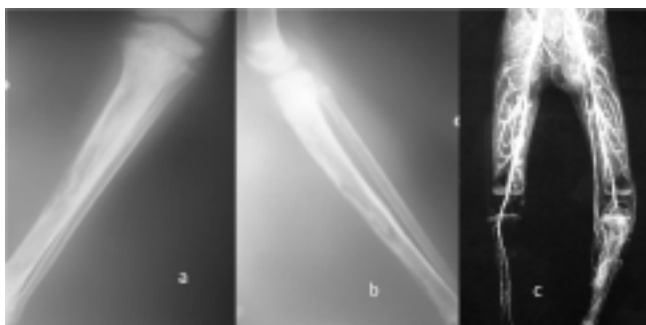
Antero-posterior radiographs at 10 days post surgery showing osteomyelitis (a,b), six weeks post operative MR venography showing recanalization of occluded vessels (c).
